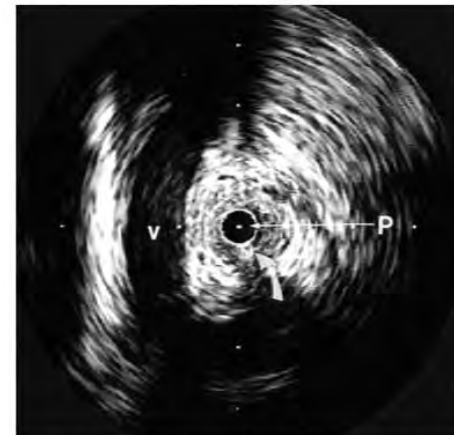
Endoluminal ultrasound image of lateral vessel crossing right UPJ. V, crossing vessel. Curved arrow represents guide wire. P, ultrasound transducer.
